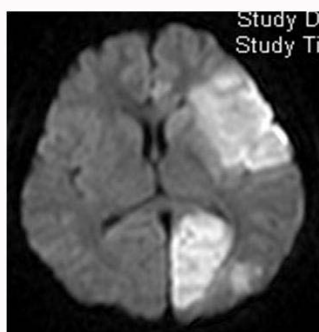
Magnetic resonance imaging of the brain showed multifocal high-intensity lesions on diffusion-weighted imaging, involving the left frontotemporal lobe, insular cortex, and left occipital lobe, suggestive of recent infarcts.
